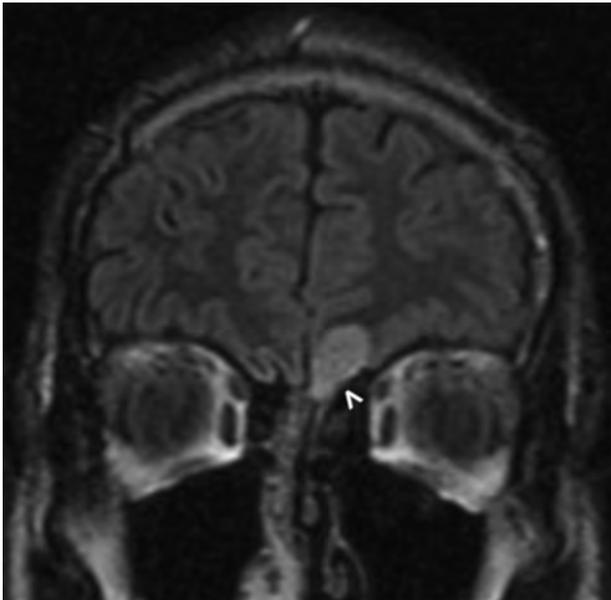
A 37-year-old man with a history of right frontal operculum GBM resected 4 years prior (case 10). Coronal FLAIR image demonstrates masslike FLAIR signal abnormality in the left olfactory nerve and surrounding left inferior frontal lobe (arrowhead), pathologically proved to reflect disease recurrence on resection.
